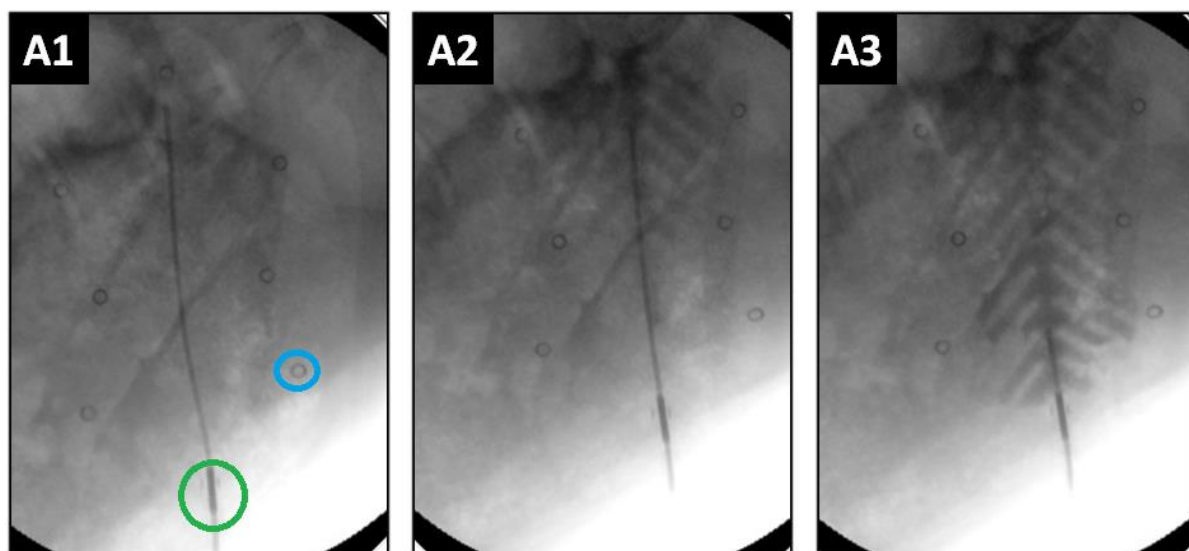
2D x-ray images of Shell A taken while filling with RGF2, with A1, A2 and A3 images taken sequentially. (A1) – Shows the filling port outlined in green, and the dark line is a filling catheter extending through the length of the shell. Radiopaque suture rings are outlined in blue. (A2) – Shows the gel filling into the base of the shell and withdrawal of the catheter to facilitate filling. (A3) – Shows the shell filling completely and withdrawal of the filling catheter from the shell.
